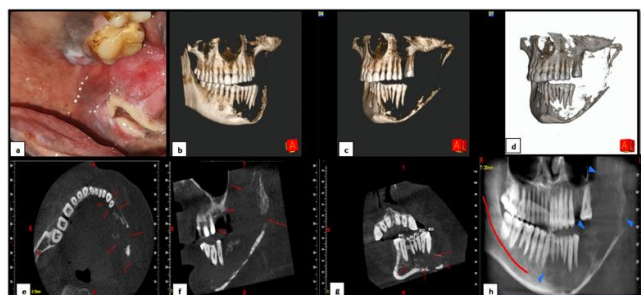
a: An ulceroproliferative lesion is seen in the left buccal mucosa extending from anteroposteriorly from the mid buccal mucosa to the retromolar region and superoinferiorly from at the level of mid occlusal plane of maxillary teeth to the mandibular vestibular region; b,c,d: CBCT- An extensive osteolytic, ill-defined destructive radiolucent lesion is noted in the mandible involving the crestal, middle, apical alveolus and basal mandible along with lower border of the mandible; e: Axial view; f: Sagittal view; g: Coronal view; h: reconstructed Panoramic View
